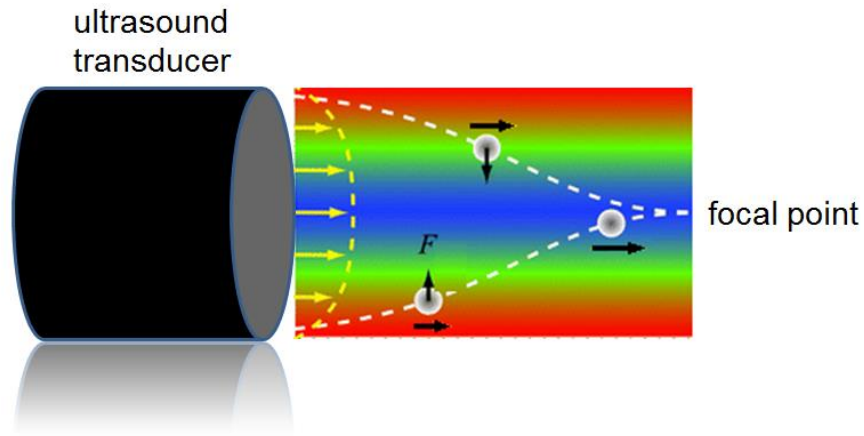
Particles within acoustic field will be forced from higher-intensity area to lower-intensity area in the parallel plane of the ultrasound surface, and spontaneously forced along the acoustic transmitting direction by acoustic radiation force.
